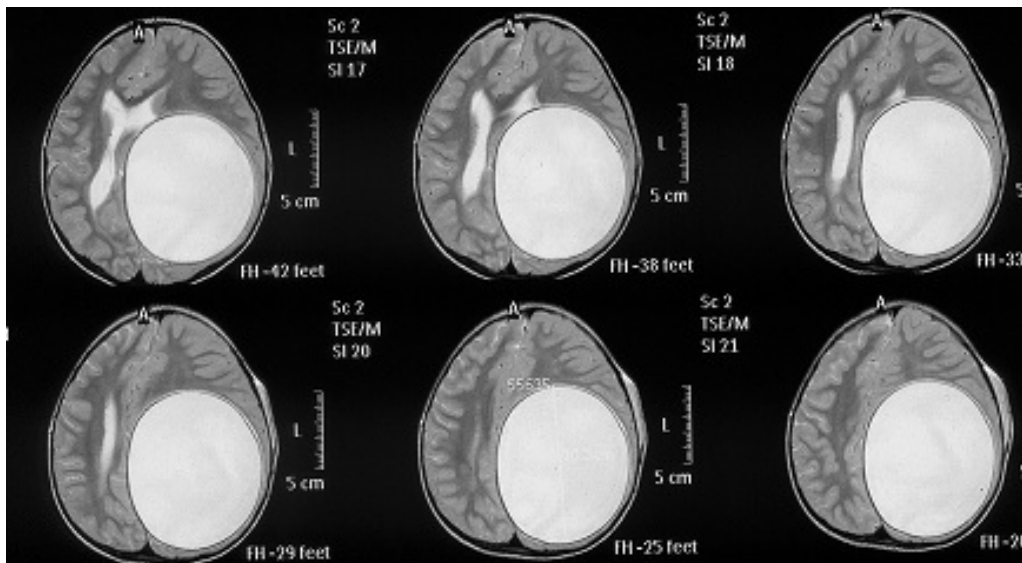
Preoperative MRI shows a cystic lesion hyperintense on T2-weighted images (similar to CSF) with a hypointense halo around the cyst capsule
